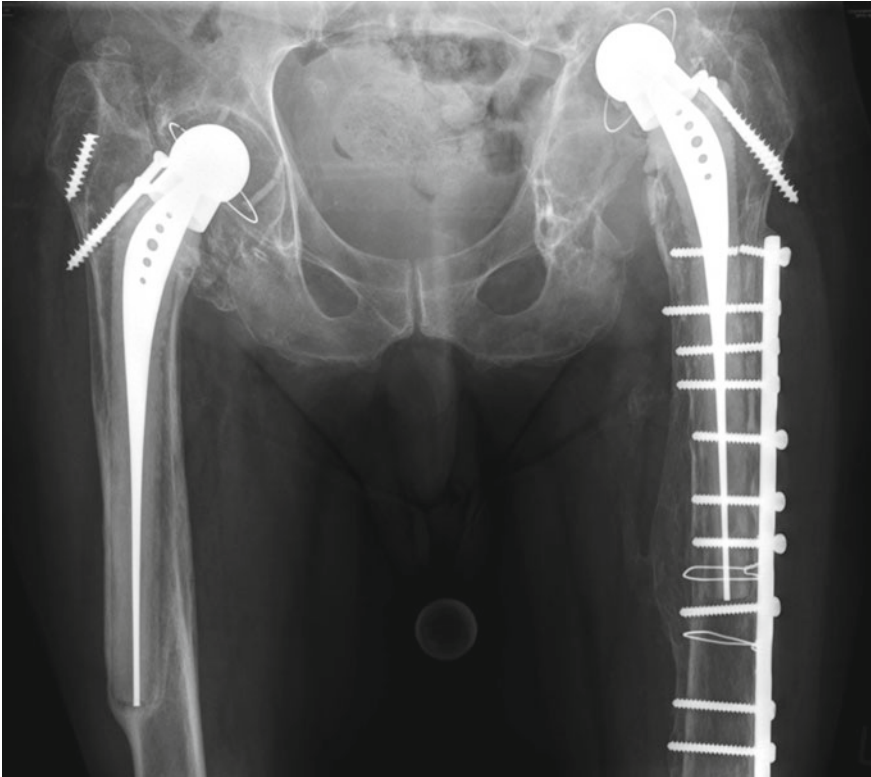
Preoperative anteroposterior radiograph of a 71-year-old patient with an aseptic loosening, and migration of the acetabular cup. A massive bone loss in the os ilium is seen
